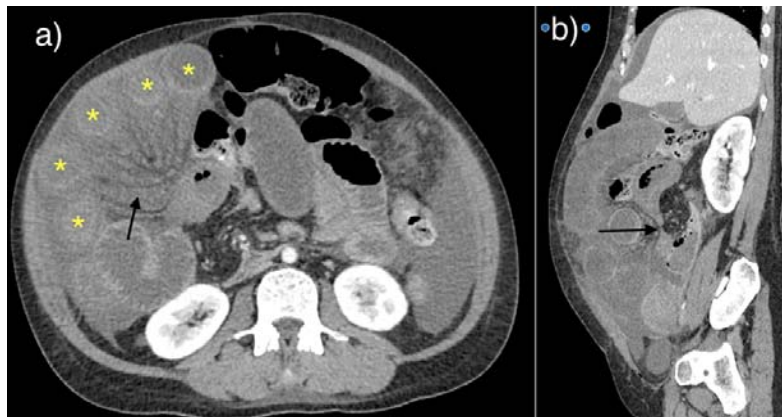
a) Axial CT scan showing distension of small bowel loops with diffuse wall thickening (*) and extensive mesenteric oedema (arrow); b) Saggital CT image showed abrupt tapering of the dilated small bowel in keeping with transition zone (arrow).
